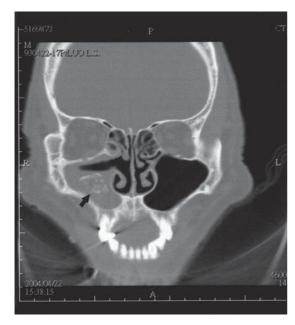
Computer tomography scanning (CT) of the sinus showed a large calcified mass (arrow) with thickened mucosa over the right maxillary sinus.
